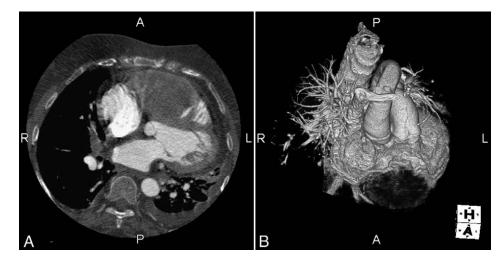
(A) Computed tomography showing relation of mass to the right ventricular wall and septum. (B) Three-dimensional computed tomography reconstruction of intraventricular metastasis.
